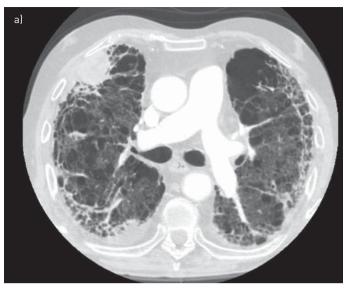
High-resolution computed tomography (HRCT) images from a 75-year-old, male ex-smoker with combined pulmonary fibrosis and emphysema syndrome (CPFE). a) HRCT image shows sub-pleural honeycombing in the middle lung, traction bronchiectasis and emphysema. On the right side a consolidation compatible with lung carcinoma is present, a frequent complication in CPFE syndrome. Echocardiography documented a pulmonary arterial pressure of 75 mmHg. b) Focal lucencies associated with paraseptal emphysema are more evident in the upper lobes in the same patient.
